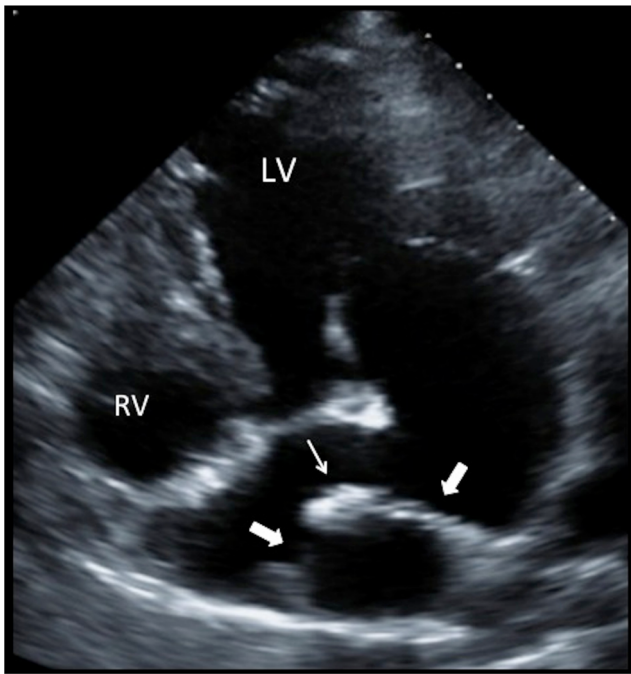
Apical four-chamber view in a patient with tricuspid atresia post fenestrated lateral tunnel Fontan palliation. At the tricuspid annulus is a fibrous band of tissue, and the right ventricle is hypoplastic. The Fontan pathway through the atrium is seen as a circular structure within the right atrium (*large arrows*). There is an Amplatzer closure device within the baffle closing a fenestration (*small arrow*) (LV left ventricle, RV right ventricle)
